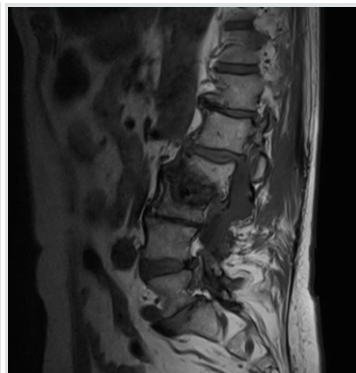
Magnetic resonance imaging of the presented case, showing a collapse of the vertebral bodies of L2 and L3.
